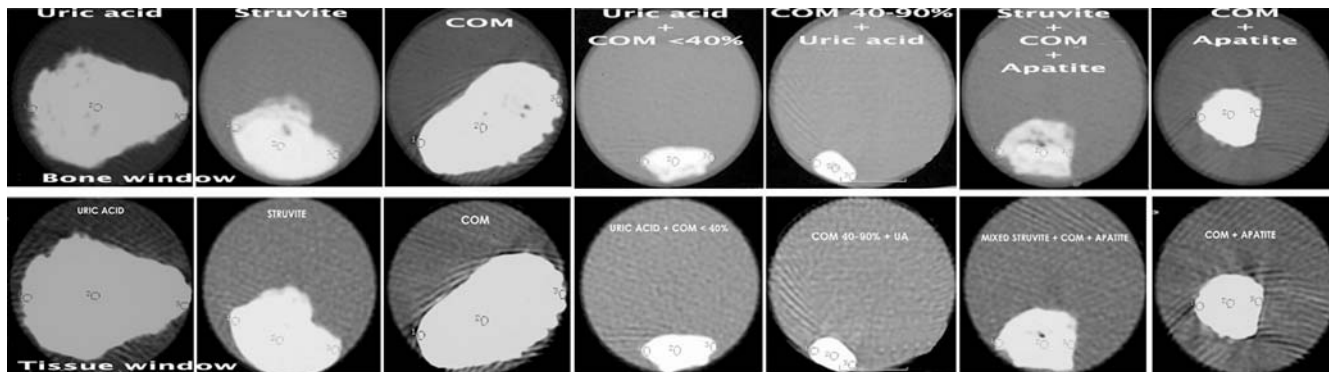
Helical CT of the stones showing the plane passing through the widest transverse diameter of the stone with the selected three ROI, and viewed with two window settings, bone window (upper row) and tissue window (lower row)
